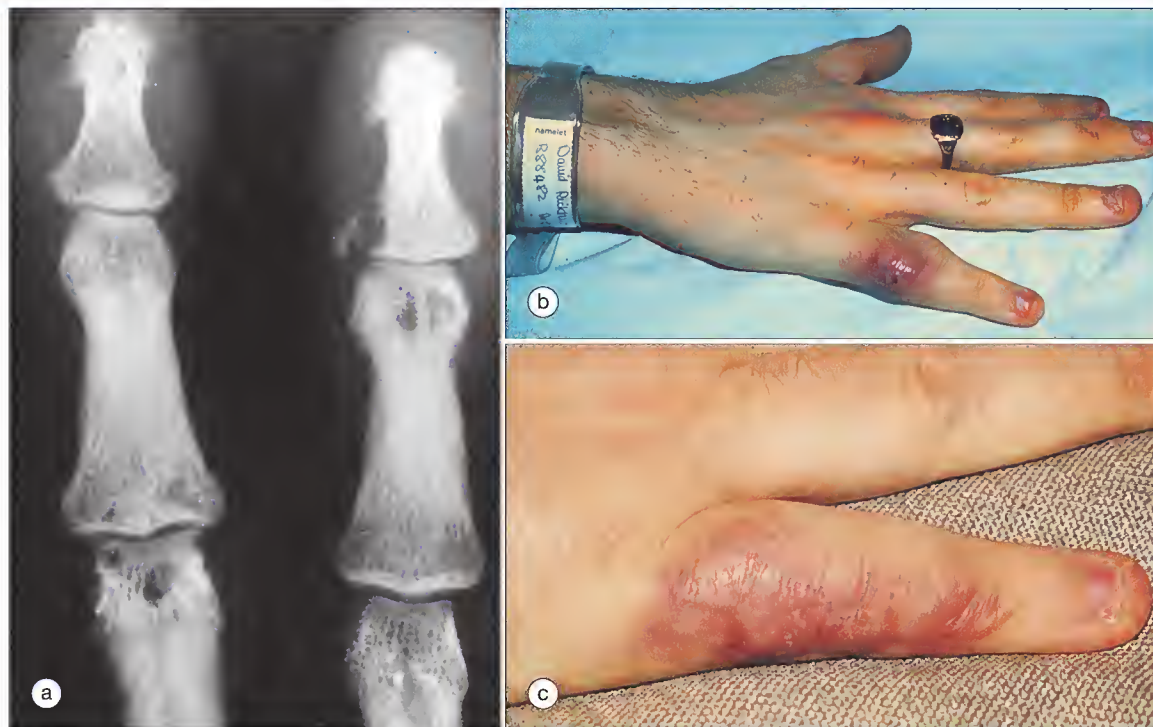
Bone cysts and sarcoid dactylitis. (a) Radiograph of small bones of the hand showing bone cysts in an asymptomatic patient with bilateral hilar adenopathy. (b) Dactylitis with underlying bone cyst. (c) Resolution of dactylitis after treatment with oral prednisolone.
